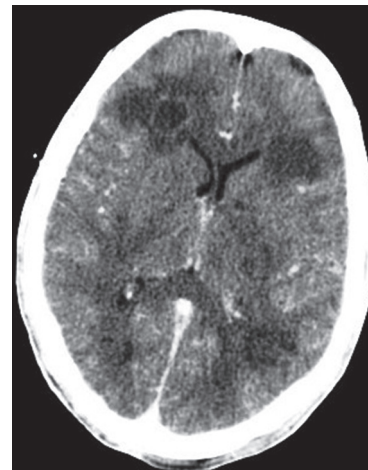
Computed tomography scan brain with contrast showing lesions
